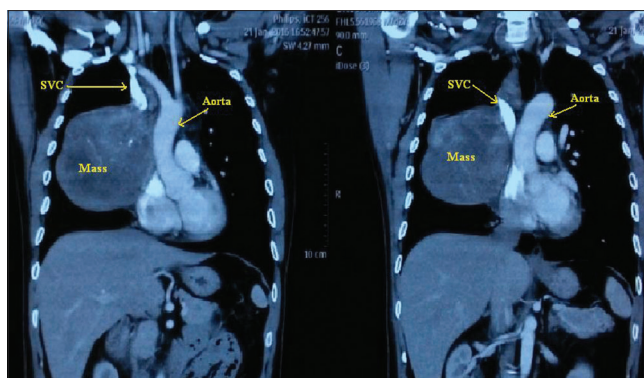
Computed tomography showing mediastinal mass encasing superior vena cava
